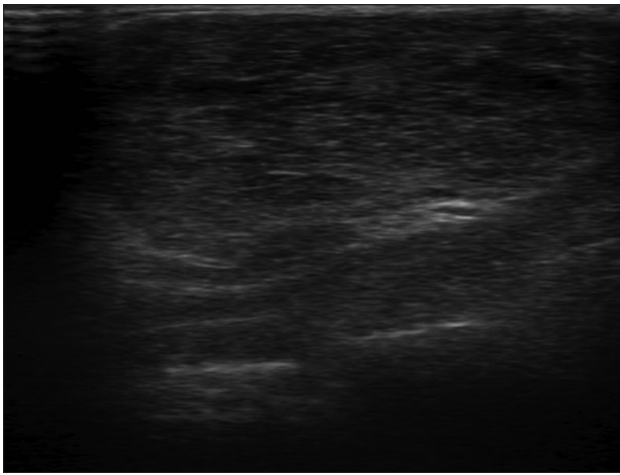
On ultrasound of the neck a well-defined rounded, heterogeneous mixed echogenic mass was seen in the right submandibular region
